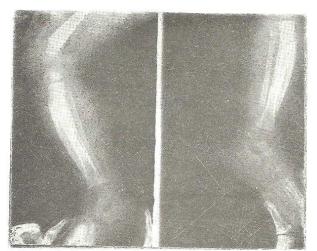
Radiographs of the tibia-fibula of the patient aged 2½ months. Note the hyperostosis of the bones.
